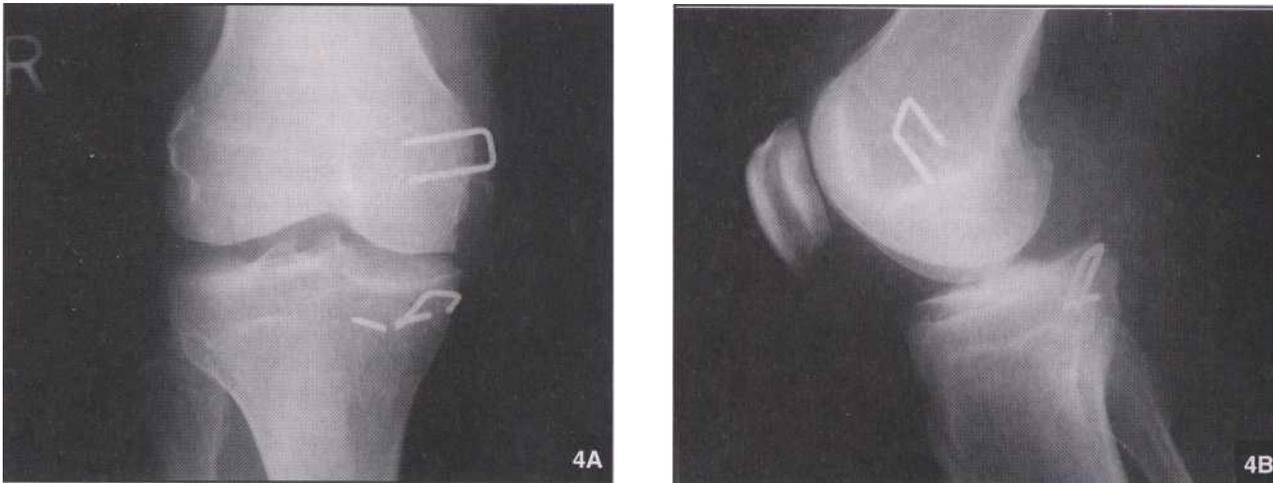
Postoperative AP (A) and lateral (B) radiographs demonstrating absence of removed loose hardware.
